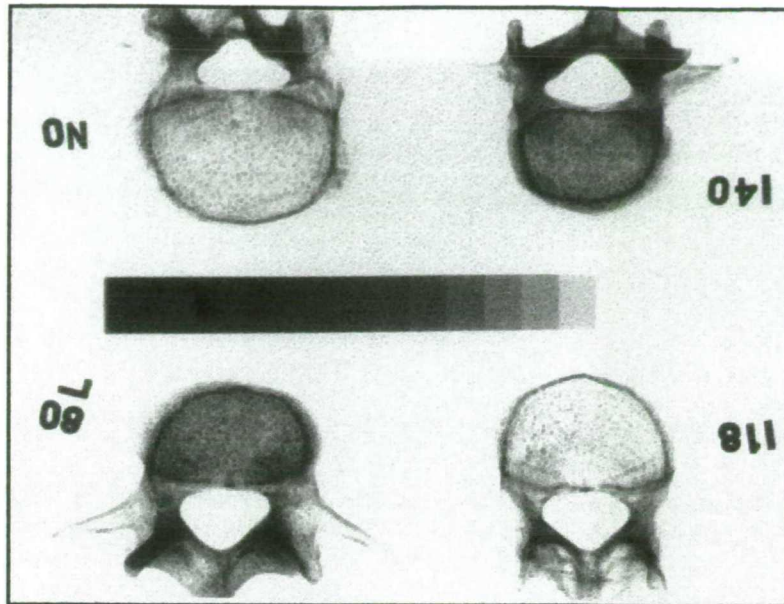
Positive X-ray images of the 4th lumbar vertebral body with large step wedge.
